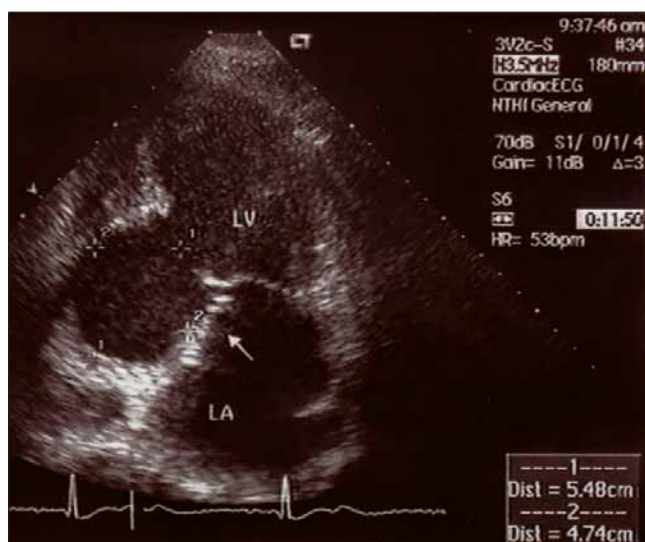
Transthoracic echocardiography showing aneurysm of basal portion of the inferior wall.
